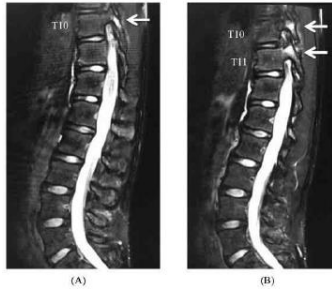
Para-sagittal STIR-MRI showing high signal changes (arrows) indicating bone marrow lesion around the articular processes of T10 and T11 vertebrae.
